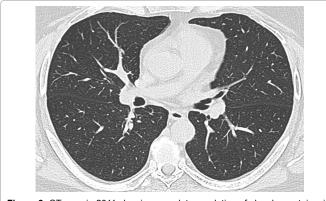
CT scan in 2011 showing complete resolution of alveolar proteinosis.
